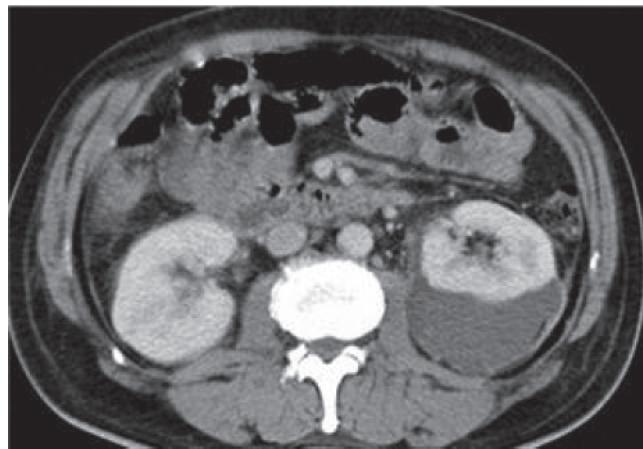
Enhanced axial CT abdomen showing the left perinephric abscess displacing the kidney anteriorly.
